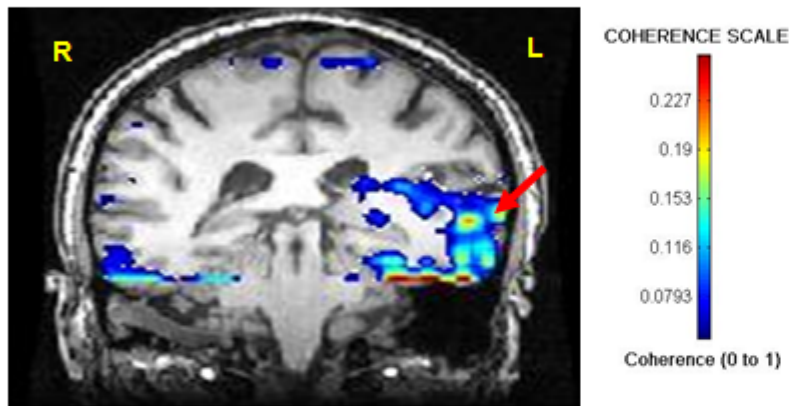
MEG Coherence analysis of spontaneous activity while a patient perceived his tinnitus. MRI shows localization of activated region in the Left Auditory Cortex. Red indicates cortical areas that are highly coherent with all other brain regions. This patient had unilateral tinnitus in the right ear.
